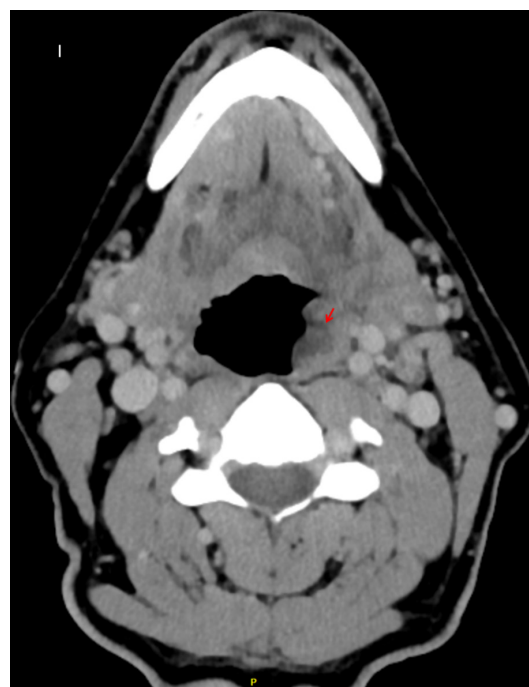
CT of the neck showing swelling of the left tonsil with submucosal tonsil oedema and enlarged, inflamed left palatine tonsil (arrow). Reactive neck lymphadenopathy was noticed as well.
